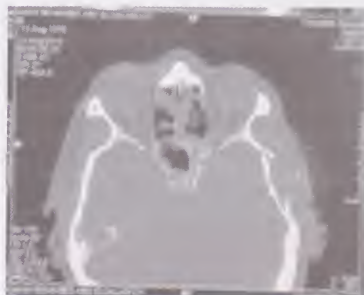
CT scan of facial bone (and its reconstructive image) showing a depressed fracture of the left temporal bone and fracture of the mandible
